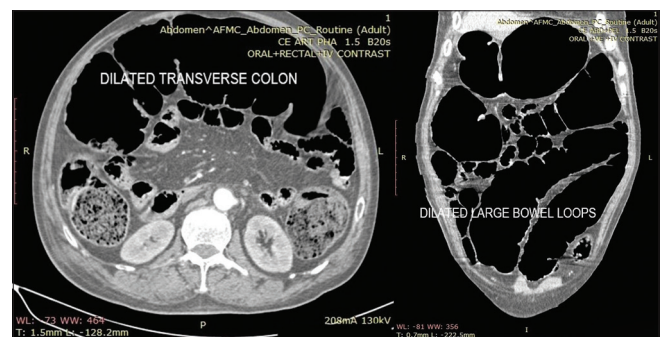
Non-contrast computed tomography image of abdomen showing dilatation of caecum and colon
